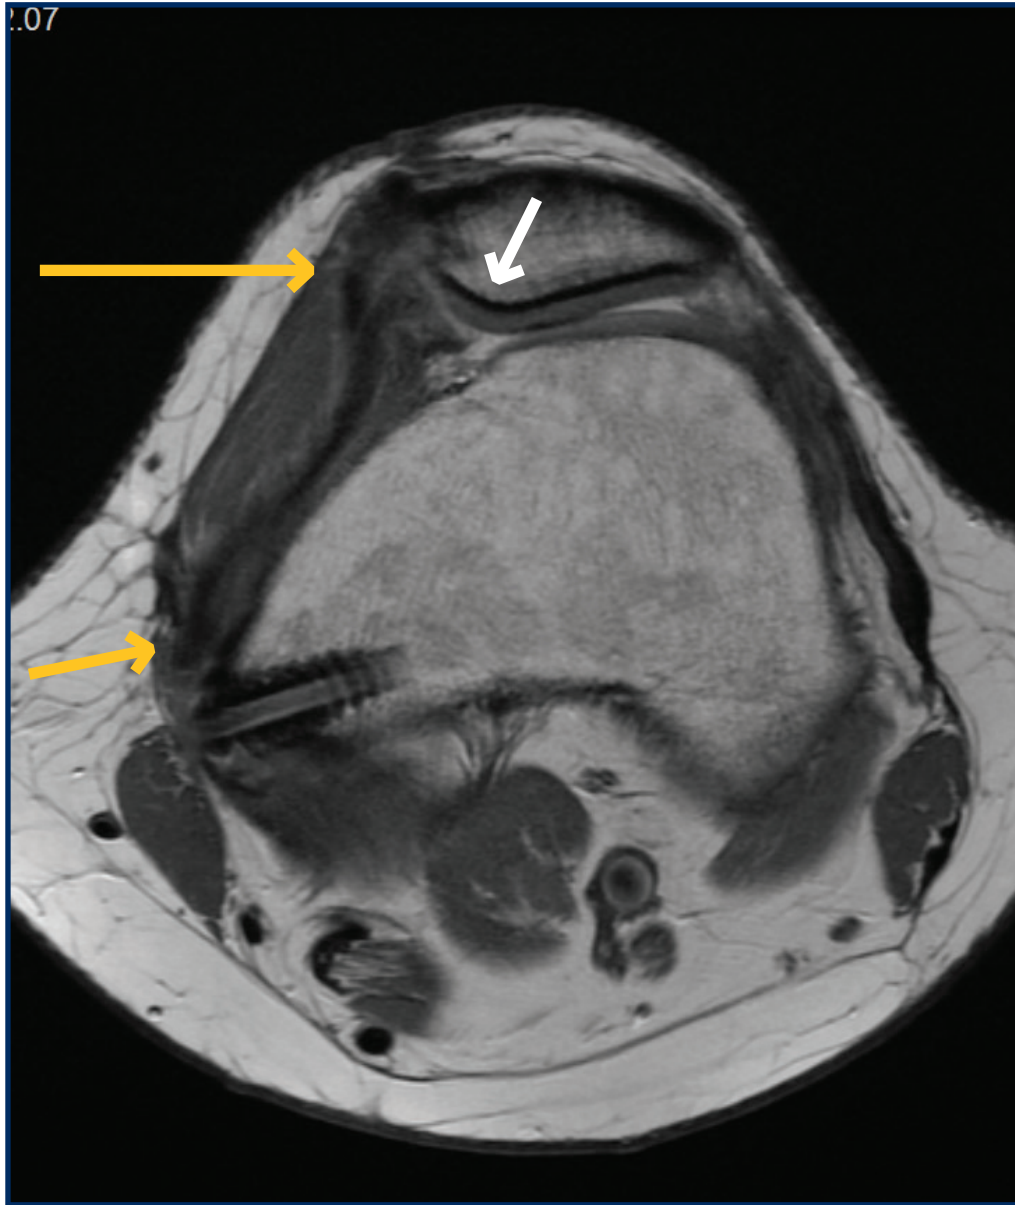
Postoperative MRI depicting reconstructed MPFL (yellow arrows) with improved patellar alignment and excellent fill of cartilage defect (white arrow).
